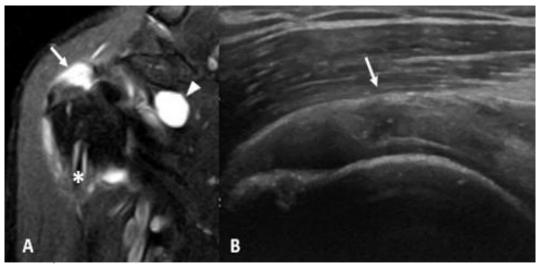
A- Coronal T2 fat saturated MRI depicting a full thickness tear of the supraspinatus (arrows). There is also evidence of a joint effusion (arrowhead). B- Longitudinal diagnostic ultrasound in the same patient showing the focal tear of the supraspinatus.
